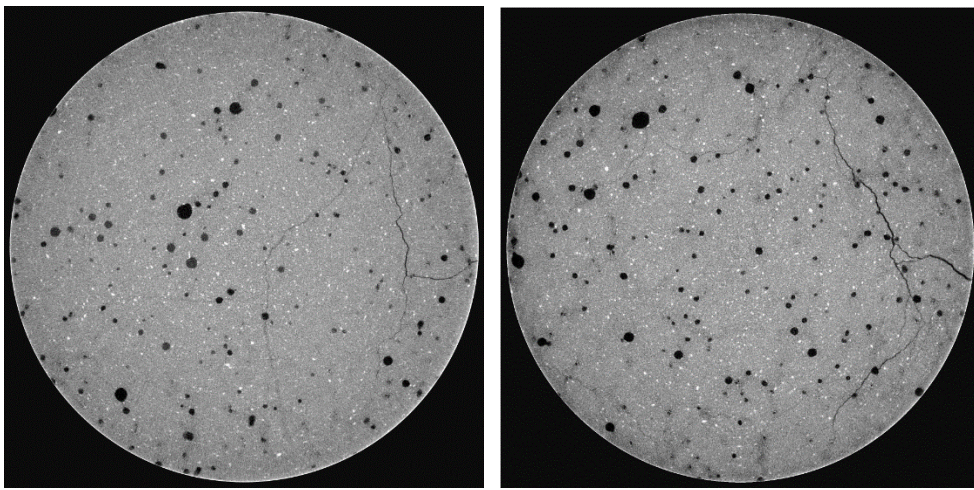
$\mu$ CT images for a thermally shocked portland cement sample.
